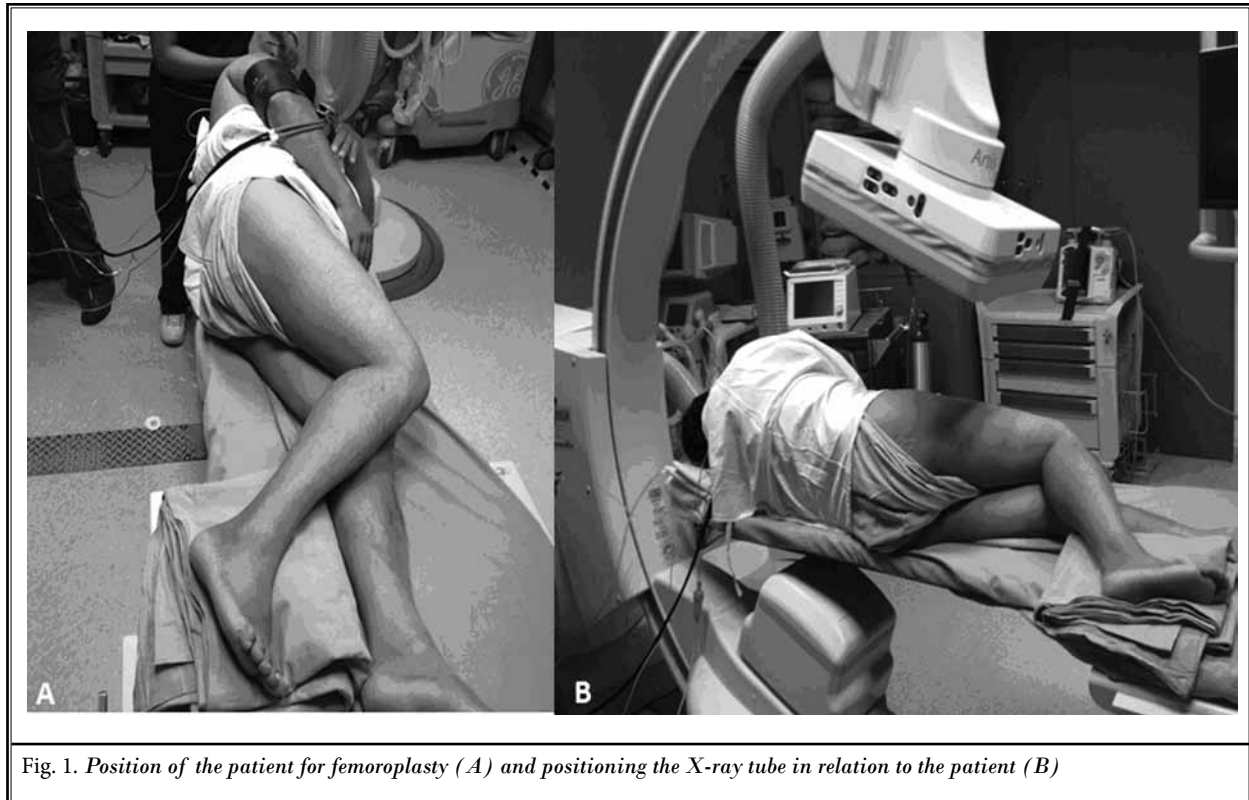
Position of the patient for femoroplasty (A) and positioning the X-ray tube in relation to the patient (B)
